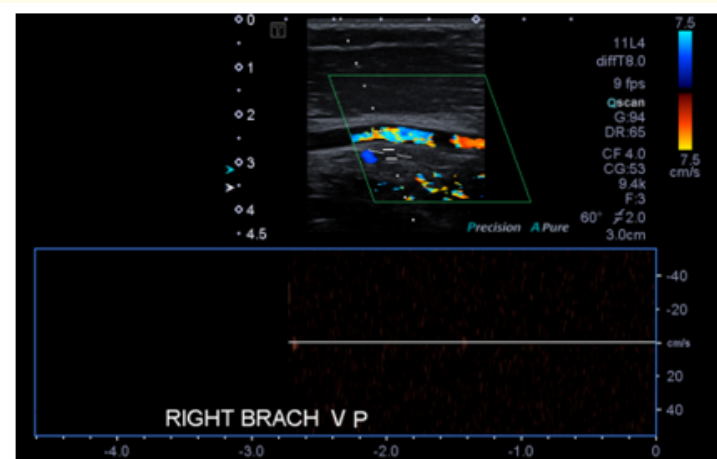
Venous doppler US showed DVT over the upper limb, localized in the Brachial vein.
